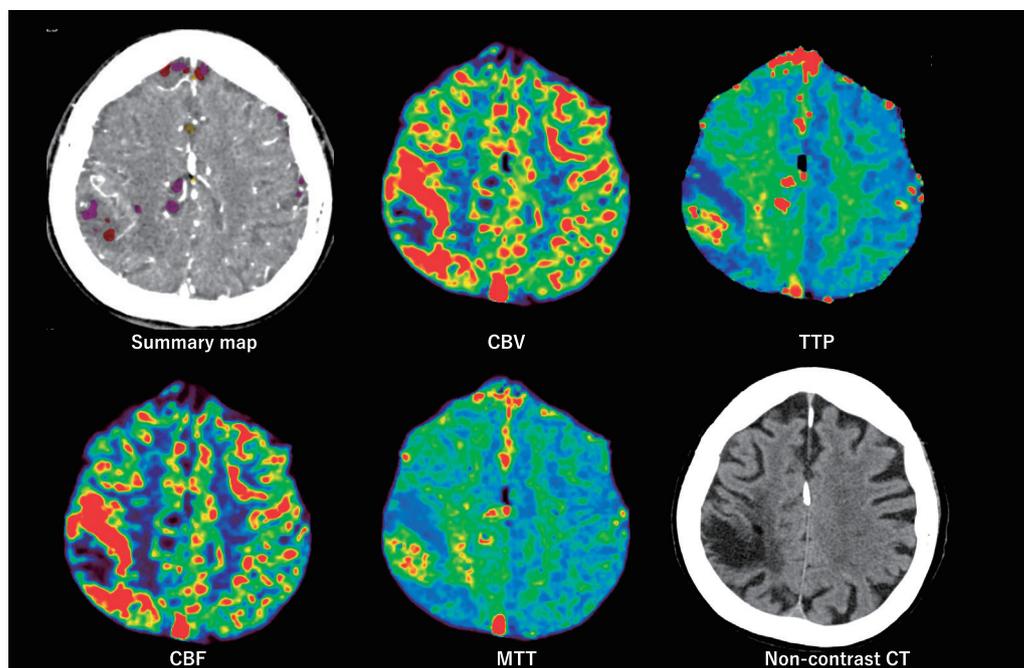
A 70-year-old man with a history of ischemic stroke in the right MCA. He was transferred to our hospital by ambulance because of sudden-onset consciousness disturbance and left-sided weakness. Non-contrast CT shows old infarction in the right MCA area. CTP in the ictal stage shows hyperperfusion with increased CBF and CBV and decreased MTT or TTP around the old infarct area (Vitrea; Canon Medical System, Tochigi, Japan). DWI shows no acute ischemic lesions. CBF: cerebral blood flow; CBV: cerebral blood volume; CTP: CT perfusion; DWI: diffusion-weighted imaging; MCA: middle cerebral artery; MTT: mean transit time; NIHSS: National Institutes of Health Stroke Scale; TTP: time to peak
